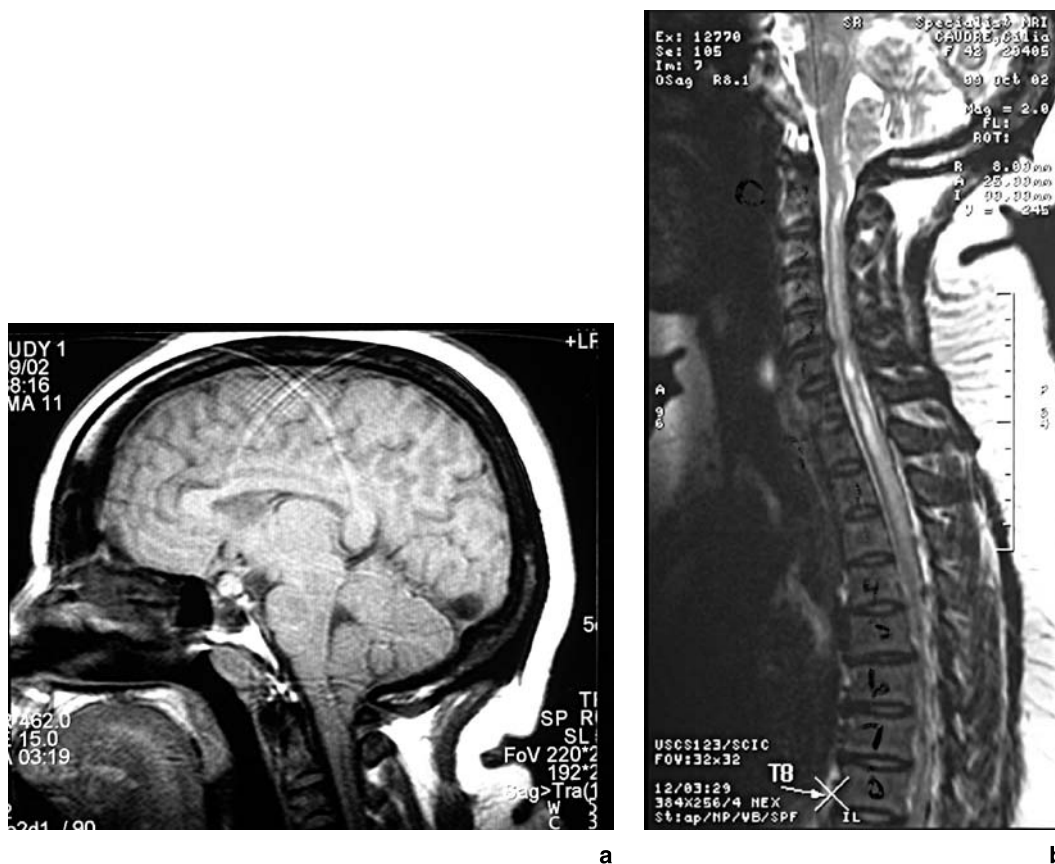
(a) T1-weighted sagittal MR image demonstrating the acquired Chiari I malformation in a patient with a lumbo-peritoneal shunt for pseudotumor cerebri. (b) T2-weighted sagittal MR image showing an extensive spinal syrinx
